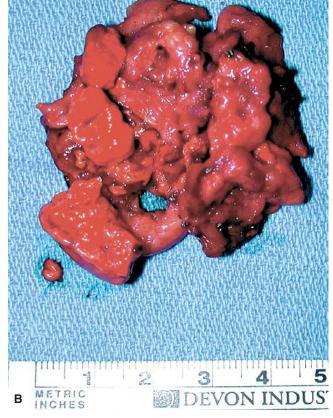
A 50-year-old woman with chronic severe hypertension and hypokalemia. Workup showed a serum aldosterone level of 20, a renin activity level of 0.4, and a ratio of 50. A thin-cut computed tomographic scan showed a homogeneous 1.5 cm left adrenal tumor in the posterior limb (*arrow*) and a normal right adrenal gland. *A*, She underwent a laparoscopic left adrenalectomy. Pathology showed a 1.5 cm adrenal cortical adenoma and micronodules with clear fascicular-type cells consistent with cortical hyperplasia. *B*, Her hypertension improved after the operation with no need for medication.
